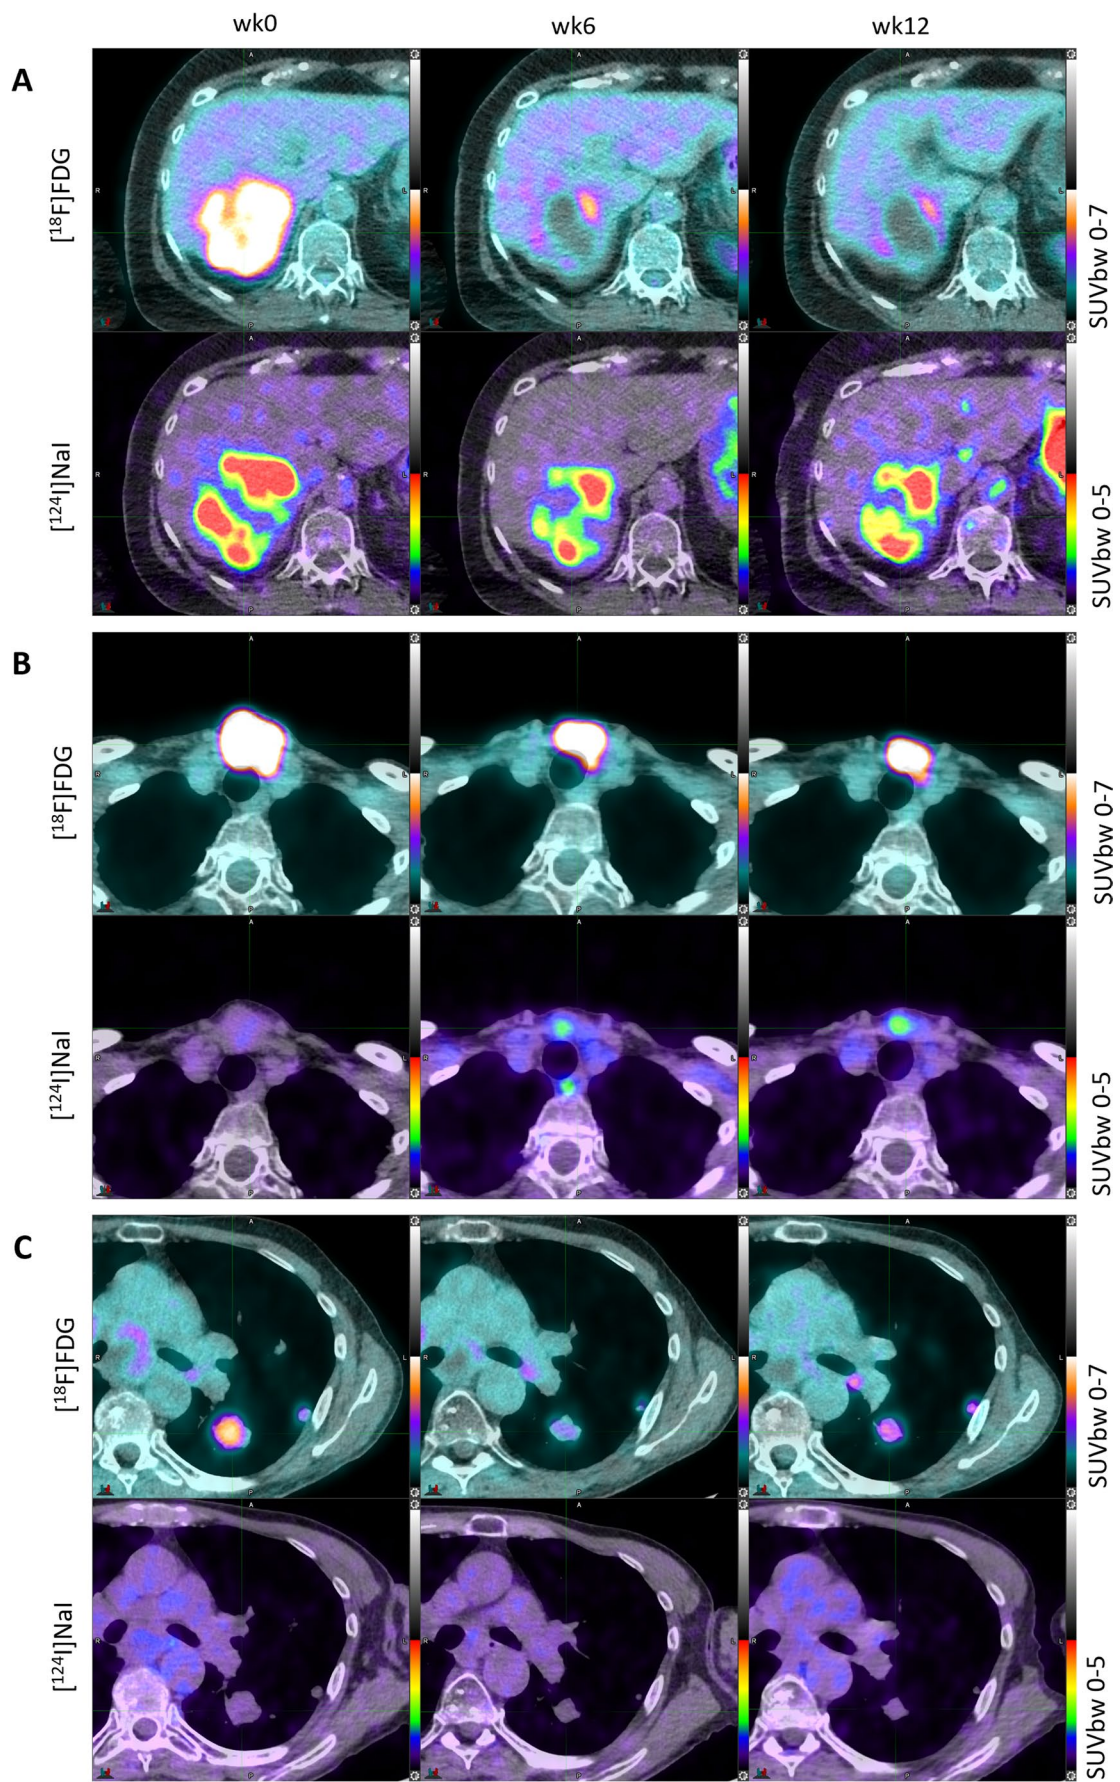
[^{18}F]FDG and [^{124}I]NaI PET/CT scans of representative target lesions of the (A) liver, (B) thyroid bed, (C) lung at baseline and 6 and 12 weeks after lenvatinib treatment
